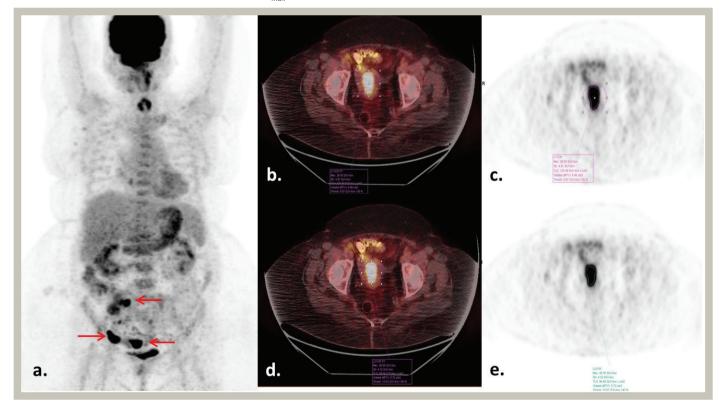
Pretreatment ¹⁸F-FDG PET/CT images of a 52-year-old patient with high-risk EC. a) MIP image with primary tumor and lymph node metastases (arrows). b, d) Axial fused pretreatment PET/CT image of the pelvis with endometrial tumor demonstrating high FDG uptake and different threshold values of MTV and TLG. c, e) Axial PET images with different threshold levels of MTV and TLG.
